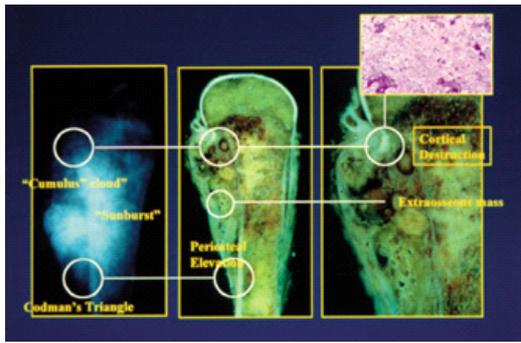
Radiographic features of primary bone tumors.
